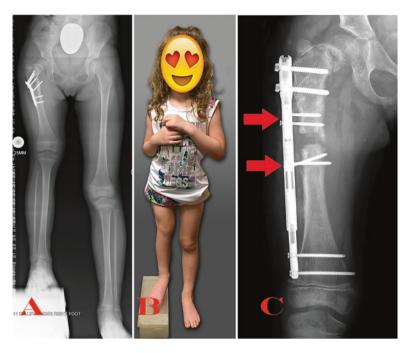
Intramedullary lengthening nail as extra-osseous lengthener in pediatric patient. (a) Standing AP x-ray image of patient after valgizing osteotomy of hip in proximal femoral focal deficiency. (b) Clinical photograph. (c) Off-label use of lengthening nail as internal distractor. *Red arrows* point to cortical screws that surround nail to secure it in place. The proximal and distal locking screws have been tapped into the implant for added stability
